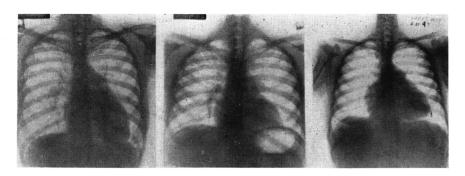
Chest x-rays of three members of the same family showing prominent pulmonary artery segments, prominent hilar vessels and normal or decreased pulmonary vascular markings.
